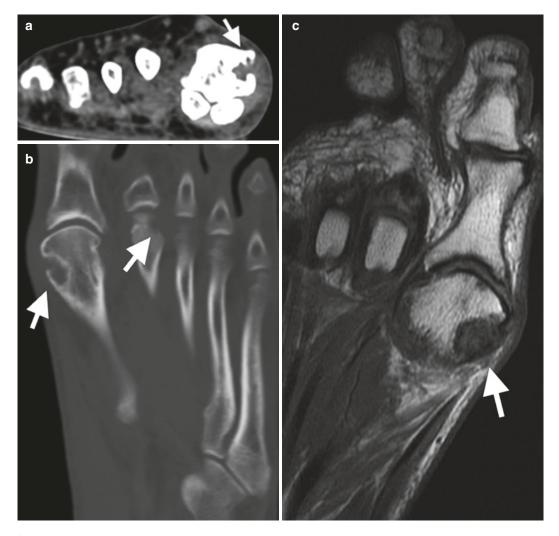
CT and MRI gout. (a) Axial and (b) coronal reformatted unenhanced CT demonstrating erosions of the 1st and 2nd MTPJs (*arrows*) with sclerotic margin and overhanging edge. (c) Cor T1, (d) Cor T2FS and (e) Sag
